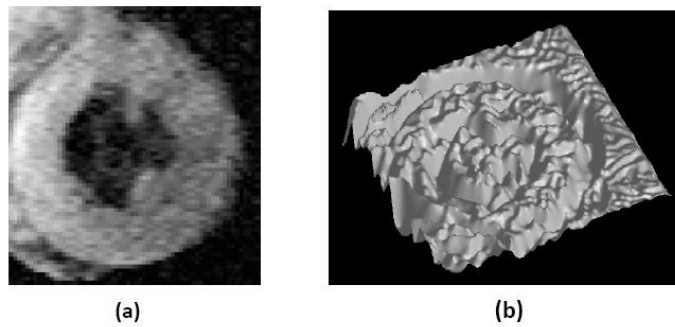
(a) A 2D MR image of the heart left ventricle, (b) A potential energy function derived [101].
